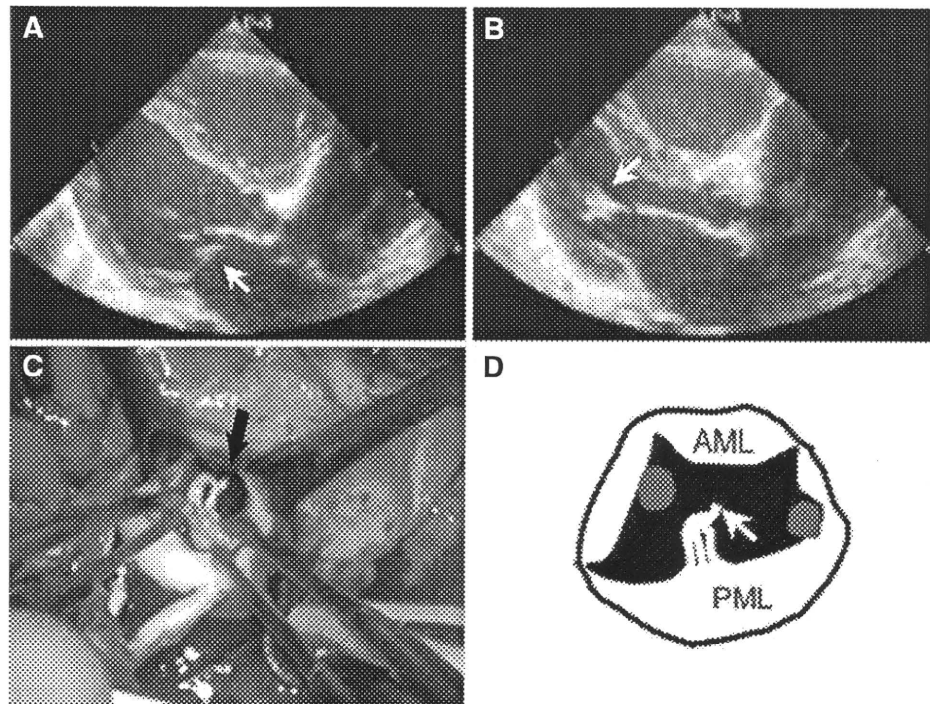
a, b Two-dimensional echocardiograms of the patient before the repair of the ruptured mitral chordae tendinae.
